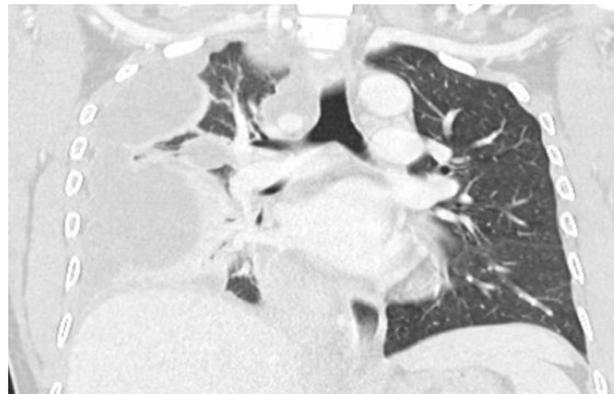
CT scan with contrast of the chest showing right-sided moderate pleural effusion with loculation extending to the major and minor fissures causing pleural enhancement. The pulmonary artery and its branches appear normal with no filling defects. Partial collapse of the right lower lung and small cavitary lesions are also seen.
